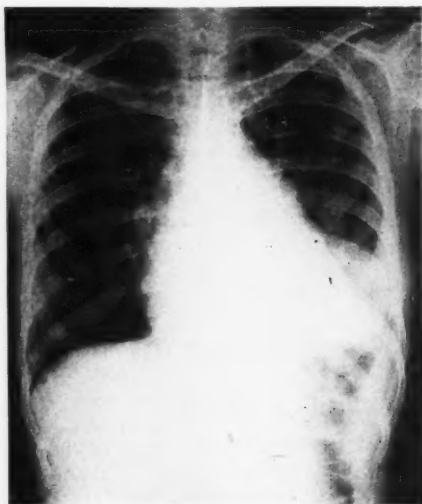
Case 4. (S. N.) Chest roentgenogram, P-A view, July 7, 1952. The cardiac silhouette is much larger than previously.
